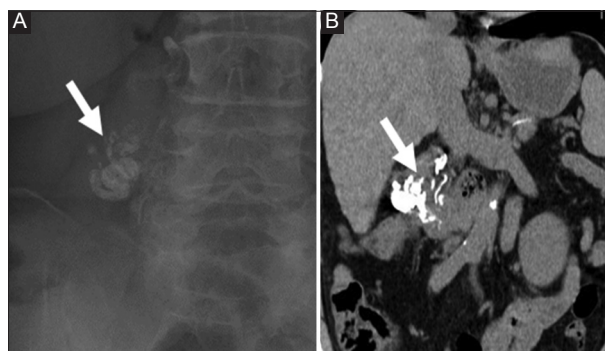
X-ray (A) and computed tomography (B) after endoscopic injection sclerotherapy showed that the injected N-butyl-2-cyanoacrylate occupied the duodenal varices (arrow)
